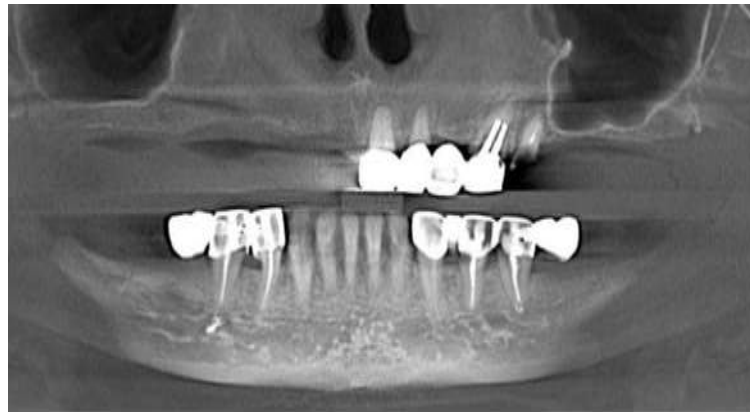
2. Cone-beam computed tomography of the upper and lower jaw. Missing teeth in the upper and lower jaw. Atrophy of the alveolar process along the height of the distal upper jaw.
